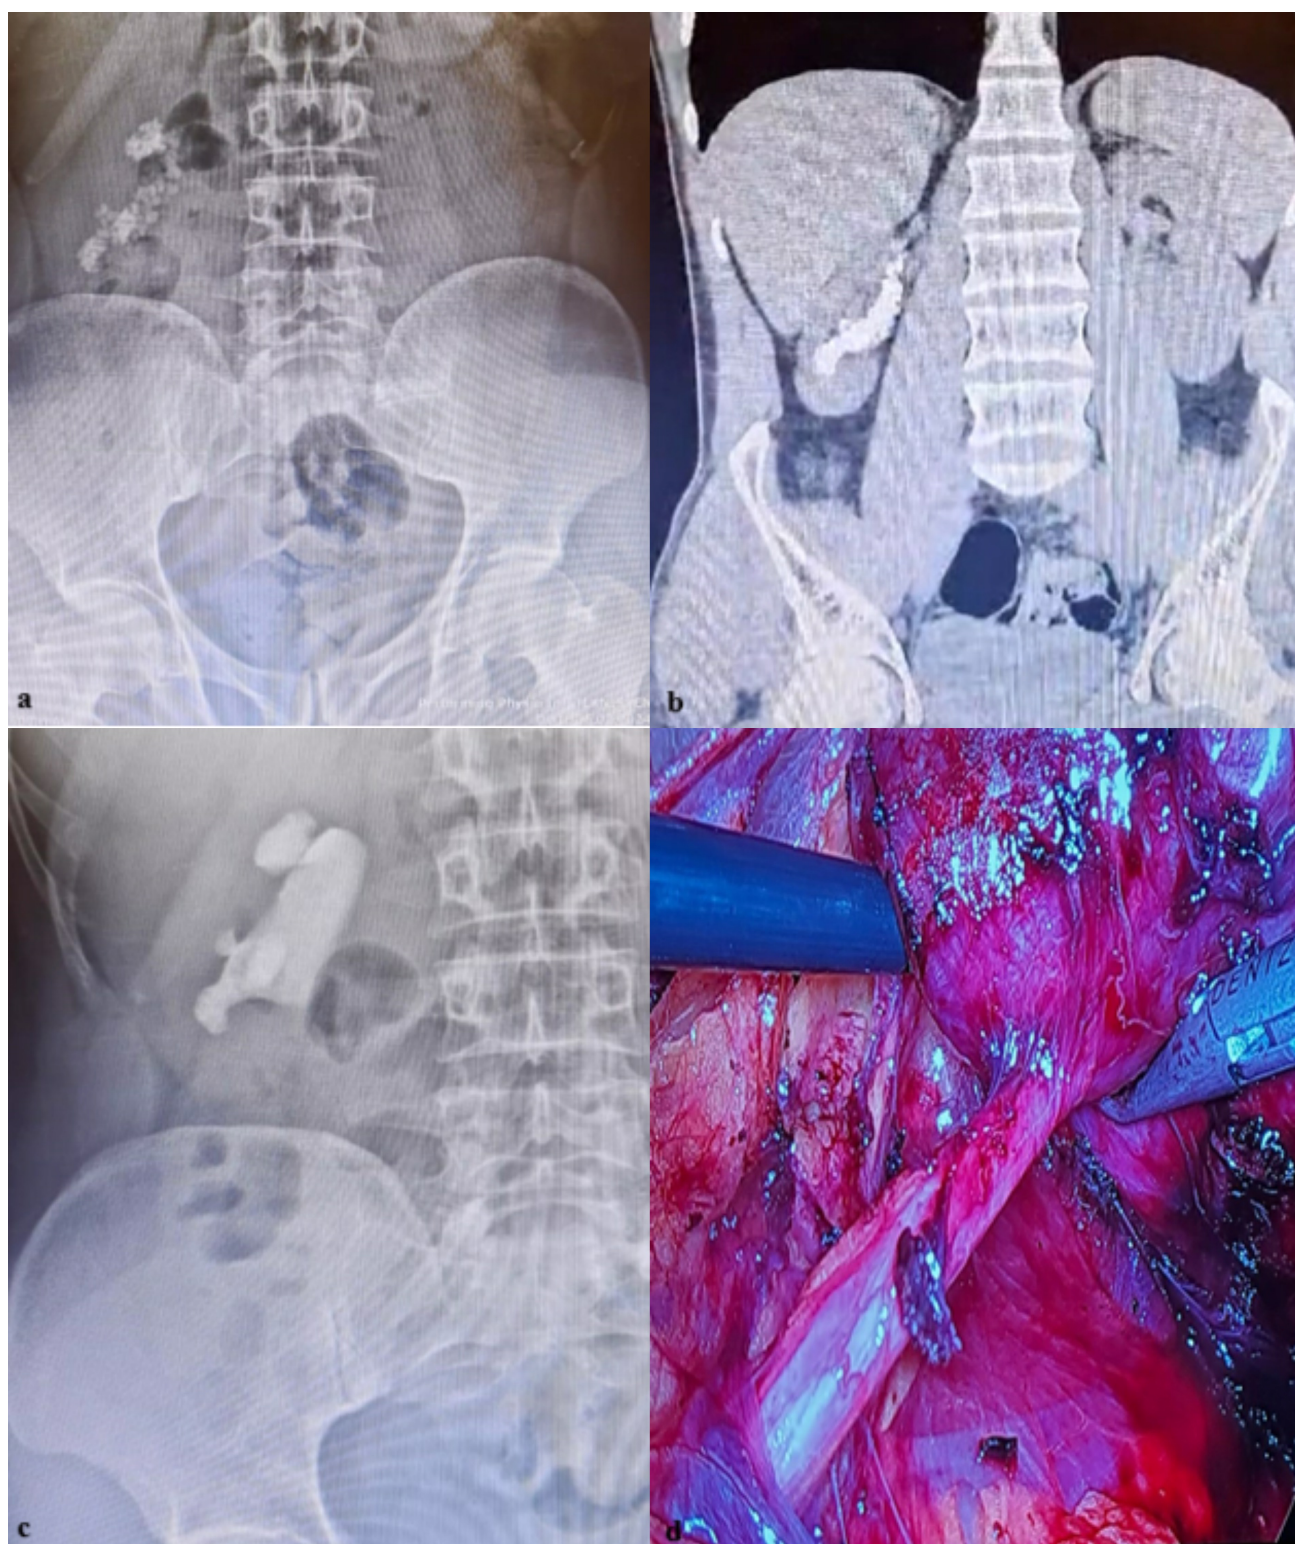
Radiological findings and intraoperatively isolated ureteropelvic junction (UPJ). (a) Kidney-ureter-bladder (KUB) radiography of the right kidney. (b) Non-contrast computed tomography (NCCT) of the right kidney with multiple stones. (c) Intravenous urography to show UPJ obstruction. (d) Isolated UPJ during laparoscopy.
